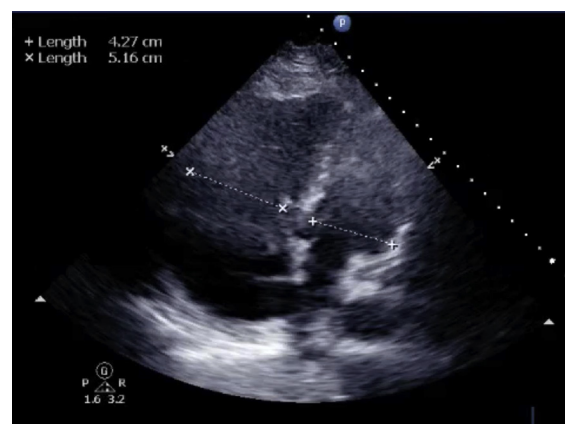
Apical four-chamber view. Still image that is directed posteriorly as the coronary sinus is seen. Although the left ventricle is foreshortened, dimensions of the right ventricle (x—x) and left ventricle (+—+) are recorded.
